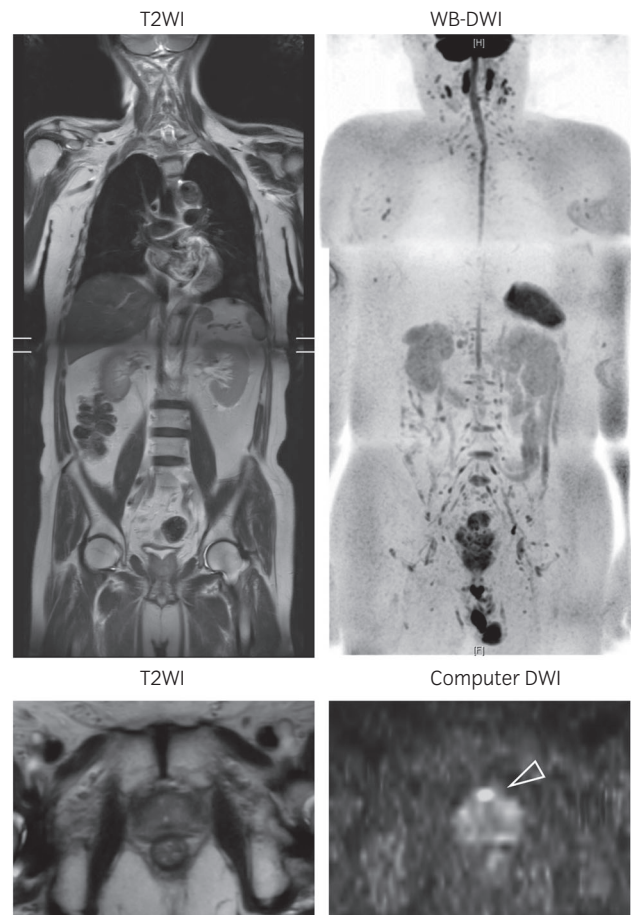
Whole-body diffusion-weighted magnetic resonance imaging (WB-DWI) showed no findings suggestive of prostate cancer metastasis. The external beam radiotherapy-resistant prostate cancer was identified as a hyperintense area on computed DWI with a b -value of 1500 s/mm² in the ventral prostate (arrowhead).
